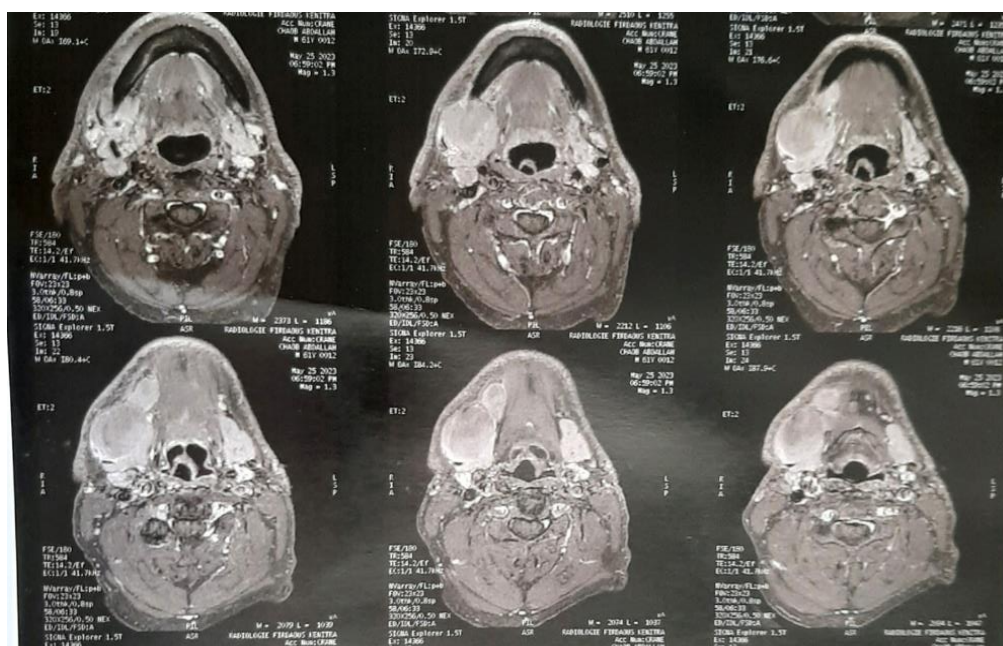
MRI showing an expansile process of the right lower vestibular gingiva lysing the horizontal ramus of the right hemimandible.
